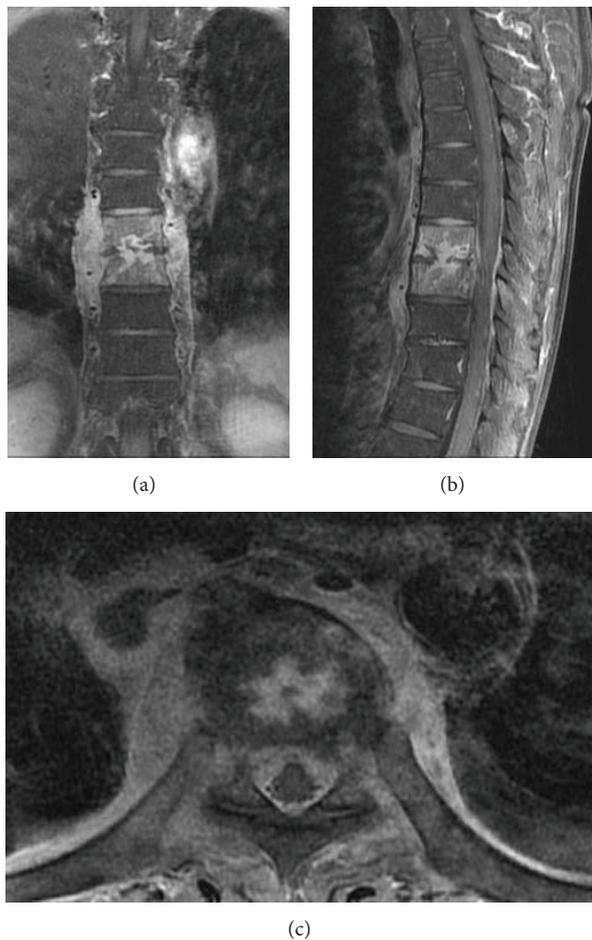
MRI evidence of T8-T9 infectious spondylodiscitis in patient number 13 in (a) coronal, (b) sagittal, and (c) axial view. T1-weighted signal with gadolinium contrast of spine MRI showed increased signal at the T8 and T9 vertebral bodies and also ring enhancement of the destroyed T8-T9 intervertebral disc.
